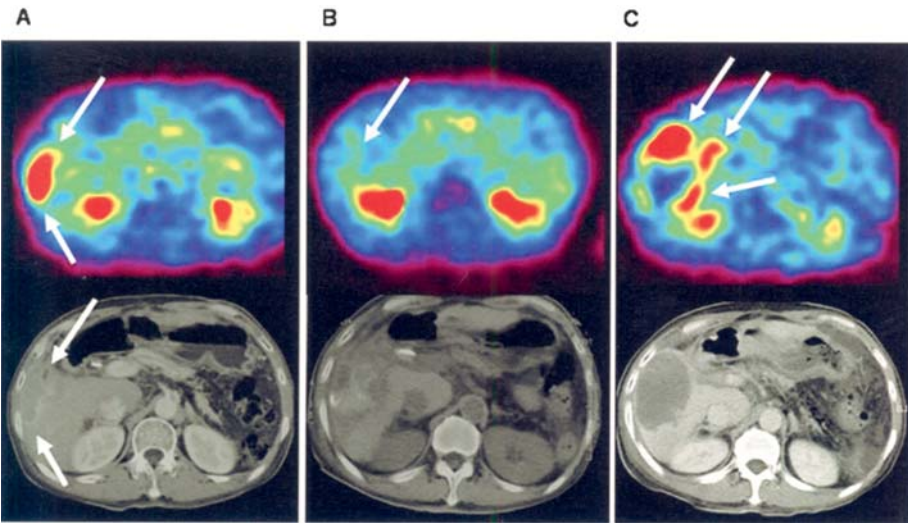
¹⁸F-FDG PET and corresponded CT before and after RFA in a patient with hepatocellular carcinoma (patient no. 8). (A) ¹⁸F-FDG PET shows abnormal uptake in the lesion (arrow) and the corresponding CT shows marginal enhancement (arrow). (B) ¹⁸F-FDG PET after RFA shows no uptake of ¹⁸F-FDG (arrow). (C) ¹⁸F-FDG PET shows high uptake of ¹⁸F-FDG in the area after RFA (arrows), although CT is not conclusive for a recurrent tumour.
